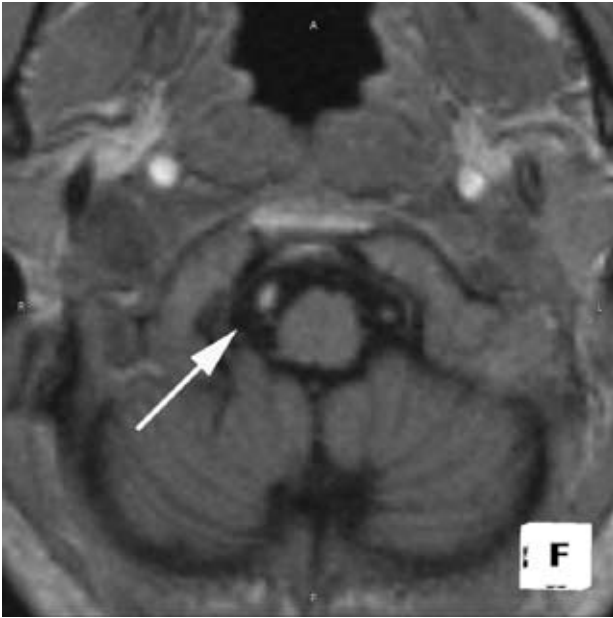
Cerebral MRI showing patent right vertebral artery
